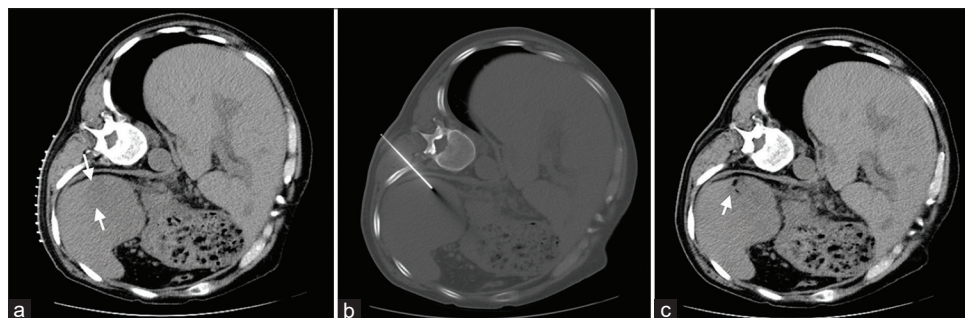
A 77-year-old male with abdominal pain and distention. (a) Computed tomography image showed splenic masses (arrows). (b) Computed tomography-guided core-needle biopsy of the splenic mass was performed via intercostal approach. (c) Computed tomography image after gelatin sponge particles mixed with hemocoagulase (arrow) was injected through a coaxial introducer needle
